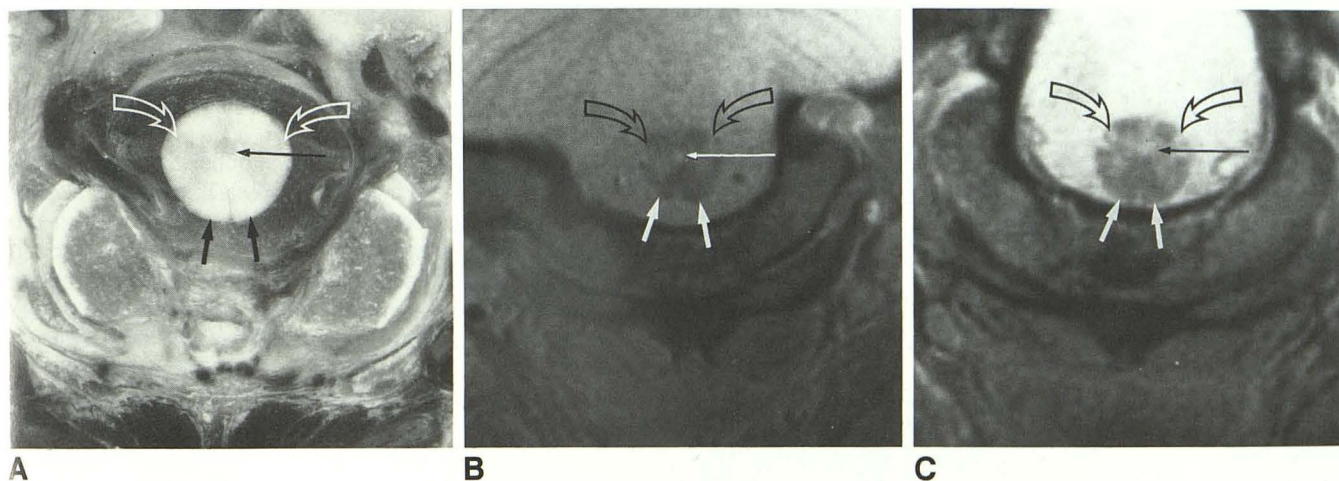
Anatomic and MR sections at level 3. Cryomicrotomic section (A), SE 800/20 MR image (B), SE 2500/20 MR image (C). Pyramidal tracts (short straight arrows), spinal trigeminal nuclei (open curved arrows), and central gray matter (long thin arrows) are landmarks at this level.
